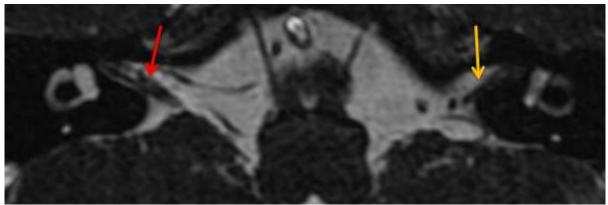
Axial MR image shows absent left VIII nerve (yellow arrow). Normal VII and VIII nerve seen on right side (Red arrow).
